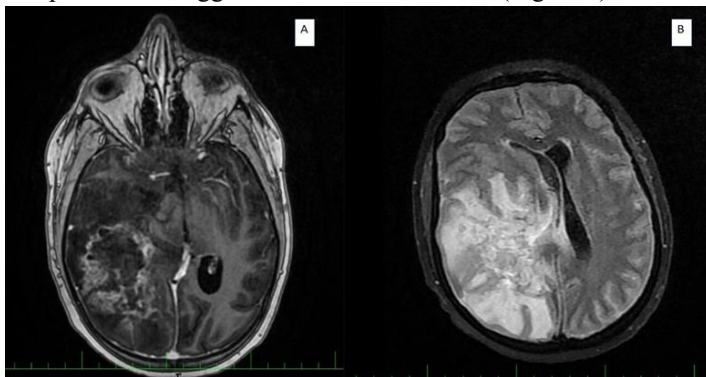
(A) Axial contrast-enhanced T1-weighted MRI with gadolinium showing a right cerebral abscess. (B) Axial T2-weighted/FLAIR (Fluid-Attenuated Inversion Recovery) MRI sequence highlighting the perilesional edematous component of the abscess. The green scale indicates lesion measurements in centimeters (cm).
